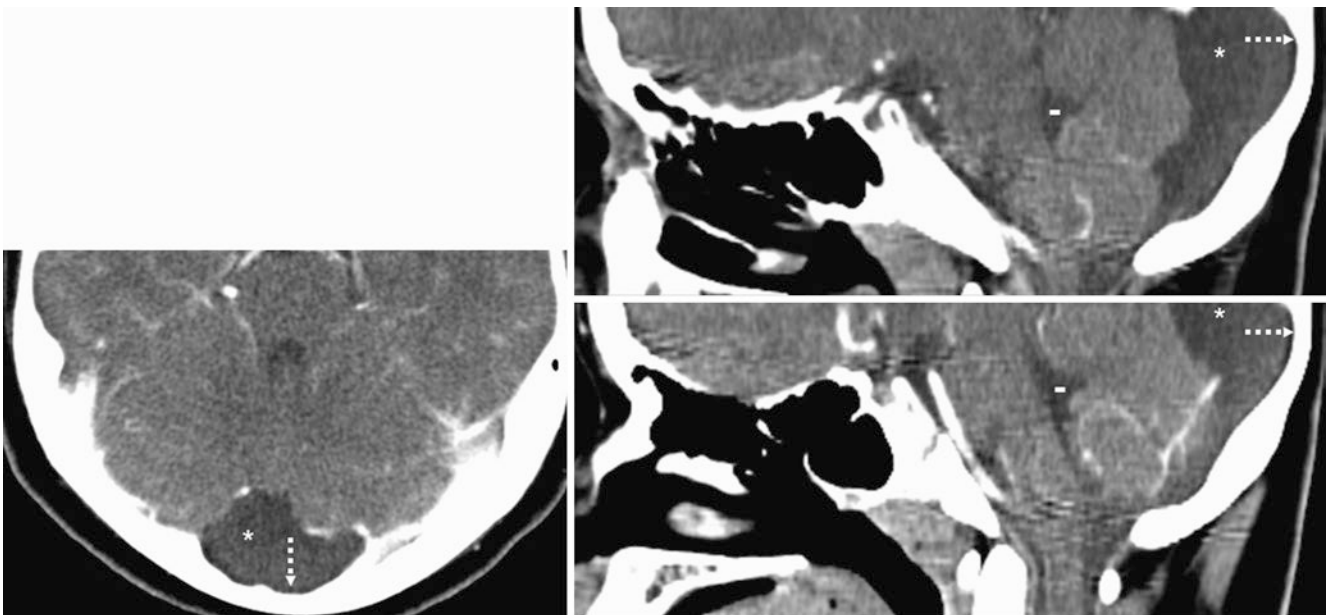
An 11 year old with CECT images obtained from the top of a neck CT. Axial (*left*), and sagittal (*right*) reconstructions demonstrate a RAC (*) that mildly compresses the superior aspect of the cerebellum to narrow the fourth ventricle (-). The falx is not identified as traversing
